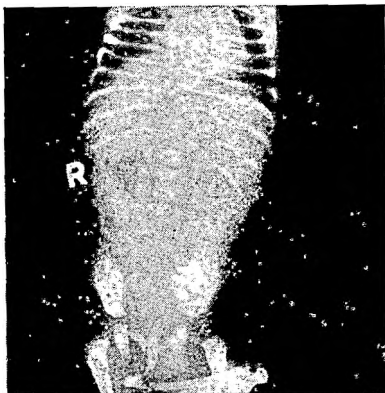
Straight X-ray of abdomen confirming the presence of congenital hypertrophic pyloric stenosis.
